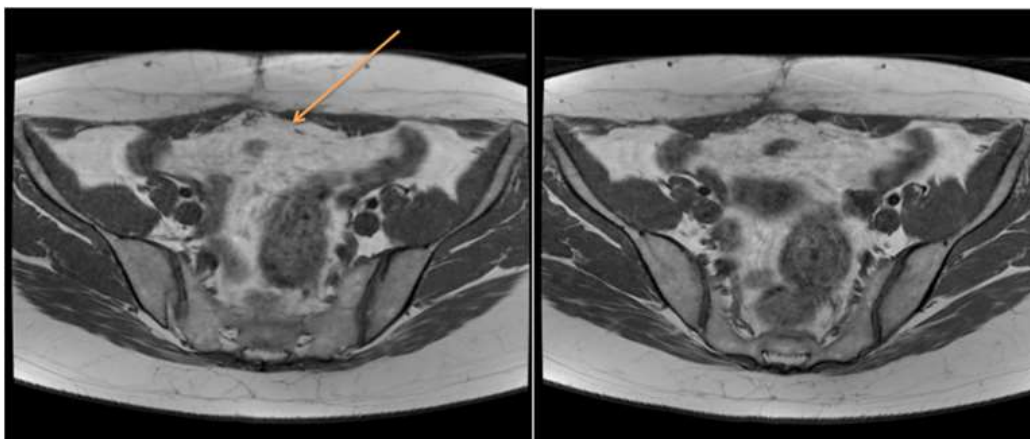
T1, T2weighted axial MR image showing a mass (high signal intensity) in the anterior abdominal wall
